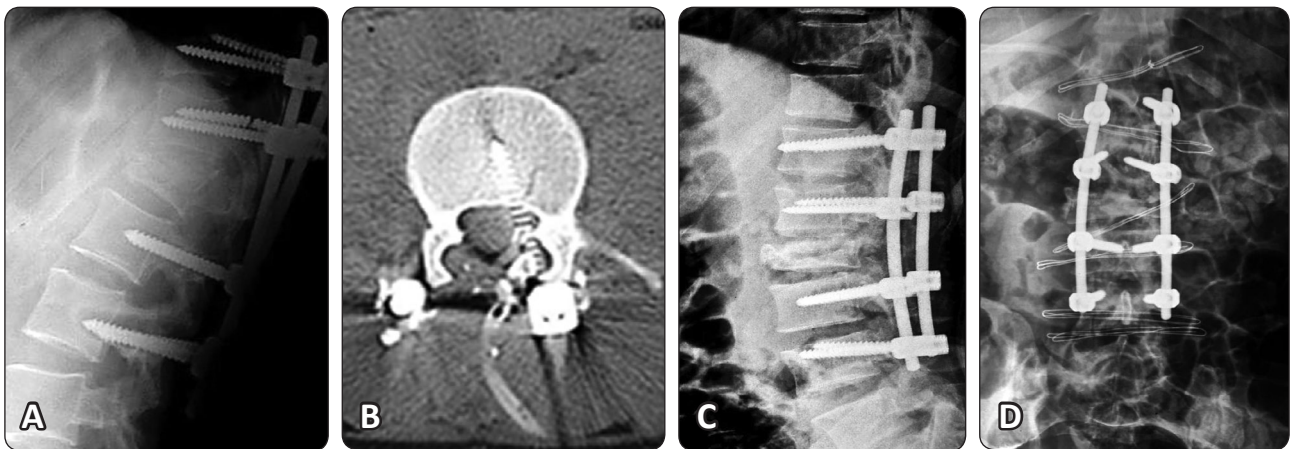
(A) Lateral radiograph of the thoracolumbar junction, in a 37 years old male patient with L-1 burst fracture, taken 18 months postoperatively. There was breakage of D12 screw with loss of correction. The breakage point was near the screw/rod junction. (B) Immediate postoperative CT scan in a 29 patient with L2 burst fracture operated for spinal fixation. CT scan demonstrated medial misplacement of a left lumbar pedicle screw. The patient developed radicular pain. Pain disappeared after screw removal and replacement with another one in the correct position. Postoperative (C) lateral and (D) AP image consequently after repositioning of wrongly placed screw for the same patient. The radicular pain improved immediately after screw repositioning.
